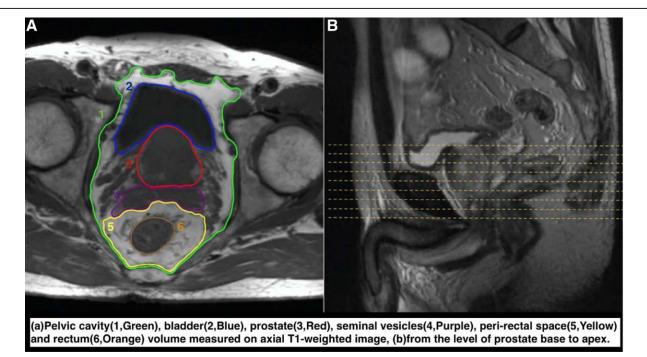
(a) Pelvic cavity (1, Green), bladder (2, Blue), prostate (3, Red), seminal vesicles (4, Purple), peri-rectal space (5, Yellow), and rectum (6, Orange) volume measured on axial T1-weighted image, (b) from the level of prostate base to apex.
